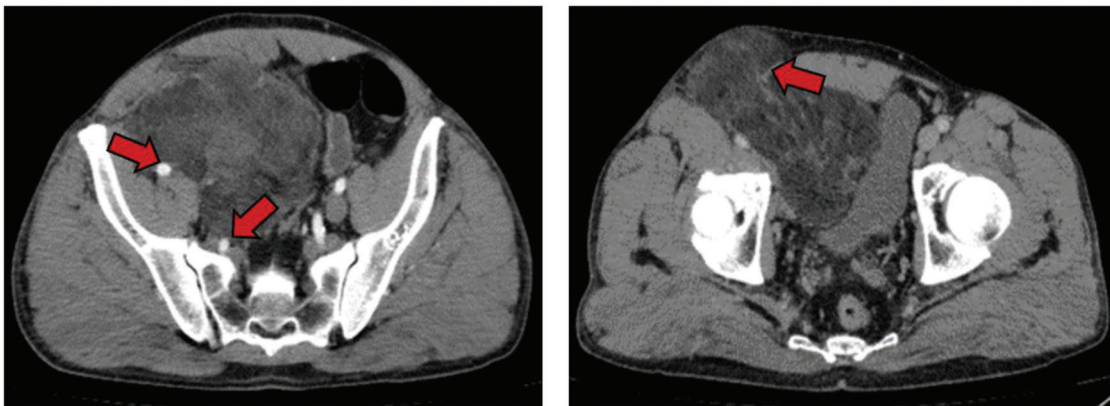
Contrast-enhanced computed tomography sections depicting important details of the tumor: the contact with the right iliopsoas muscle and pelvic iliac segment of right ureter, common iliac, and external iliac arteries as pointed by the arrows on the left. The tumor extends through the inguinal ligament to the inner thigh as depicted by the arrow on the right.
